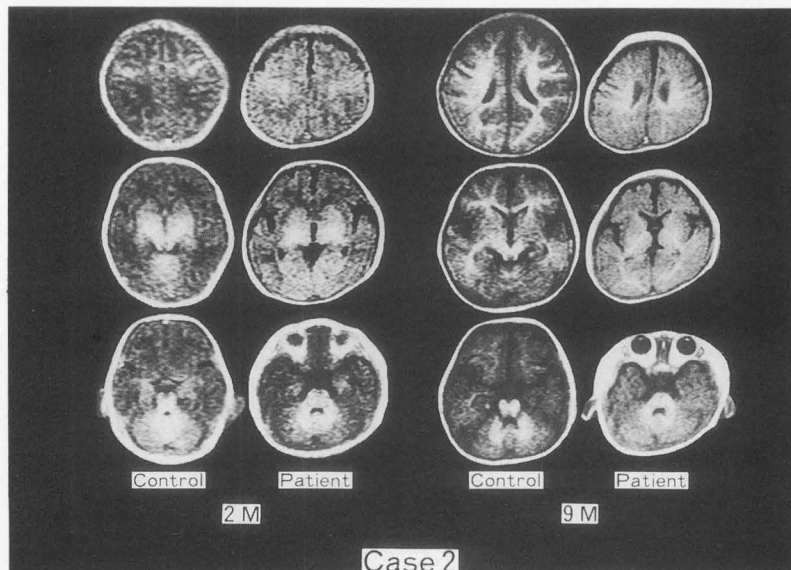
MRI on IR (2100/500) scans in case 2 disclosed no abnormal findings at two months old (Left), and the delay in the myelination of white matter at nine months old compared with in an age-matched control (Right).
